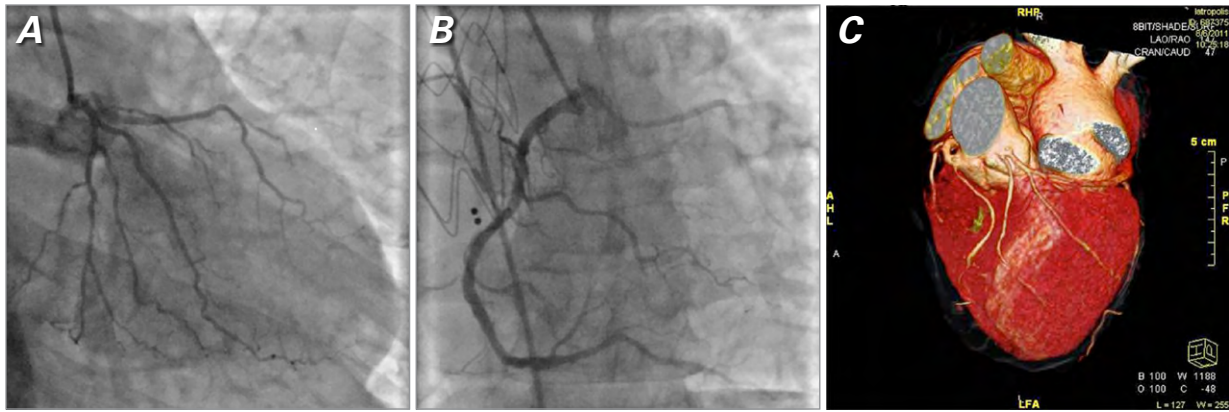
Coronary angiograms of the A) left and B) right coronary systems. C) Computed tomographic angiogram shows the 2 left coronary arteries arising from separate ostia above the left coronary sinus.
